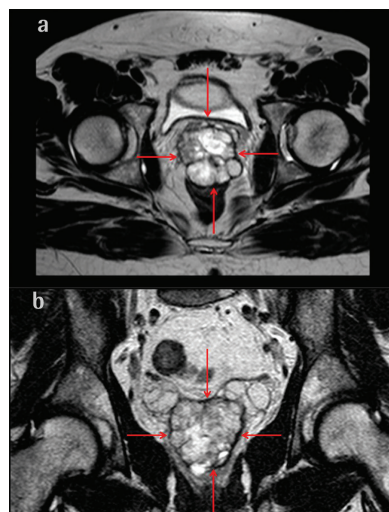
Axial and coronal turbo spin echo T2-weighted images reveal a well-defined, macrolobulated heterogenous hyperintense lesion with hypointense areas within prostate gland (red arrows)
